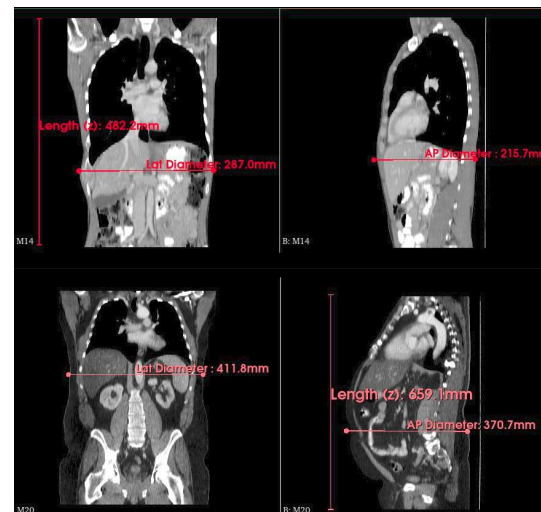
CT images of two male patients, low BMI (M14 18 kg/m²) and with a high BMI (M20 39.8 kg/m²)
